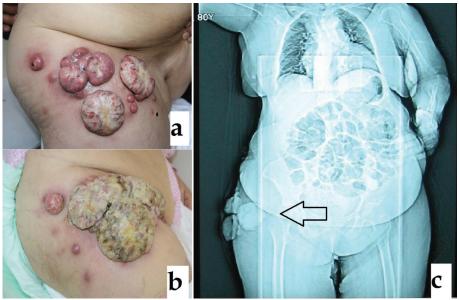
a) Nodular and tumoral lesions with a wide base, hard, tender on pressure, varying in size from about 1 to 5 cm in the lateral part of the right thigh, b) rapid growth of the lesion after 2 weeks, c) primary cutaneous squamous cell carcinoma with right inguinal and right iliac lymph node metastases confirmed by CT scan.
